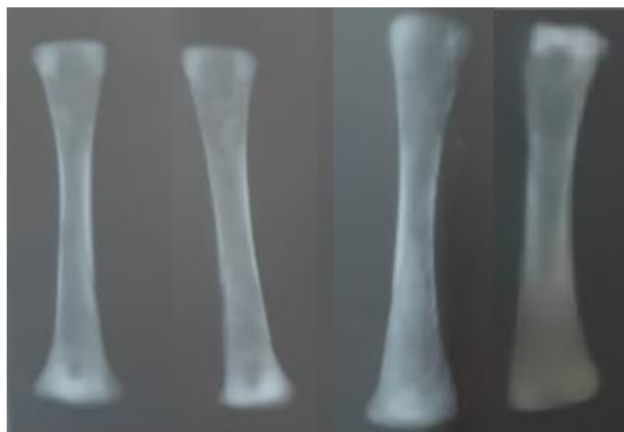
Radiographic images were taken on tibia to study the effect of different treatments on tibia bone mineral density
